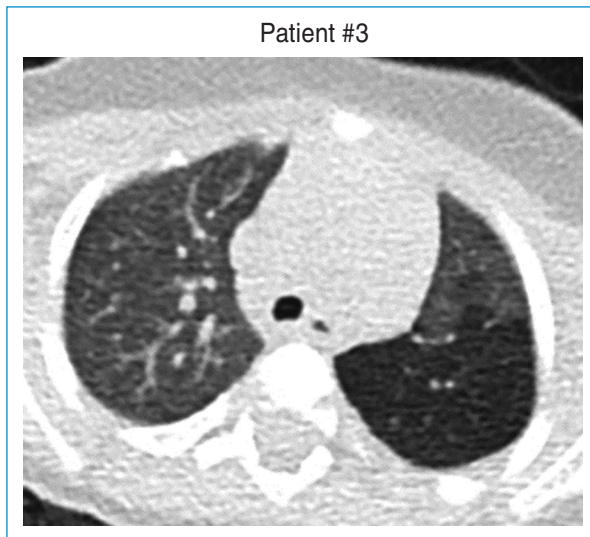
CT scan at 6 months of age: minor right posterior CLE; no atelectasis or mediastinum shift.
